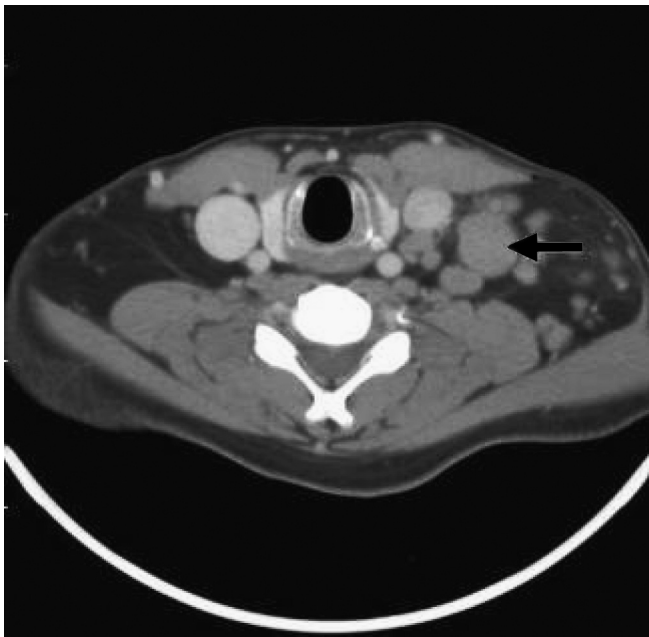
Computed tomography scan of neck demonstrating a cluster of enlarged lymph nodes involving the left supraclavicular fossa, with the largest one measuring 2 cm in short axis (arrow).
